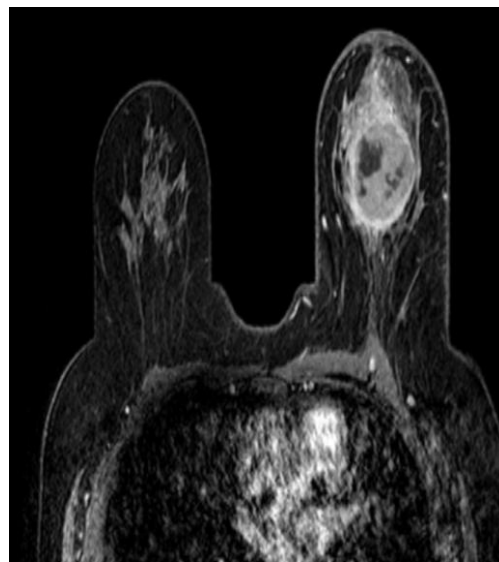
Well-circumscribed margin with capsular/rim enhancement on MRI.
